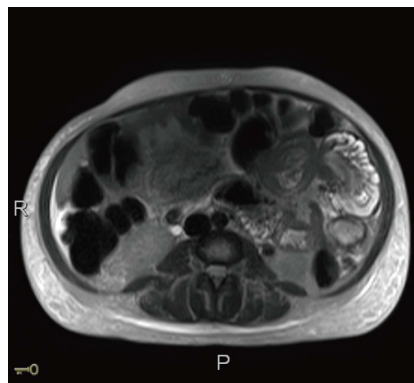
Magnetic resonance imaging of abdomen showing entero-enteric intussusception in axial cut.
